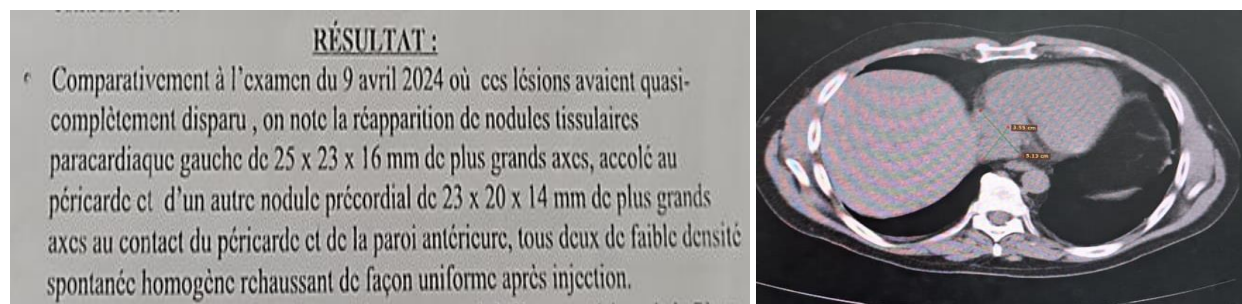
image and report of chest CT scan showing recurrence of the para-cardiac mass
